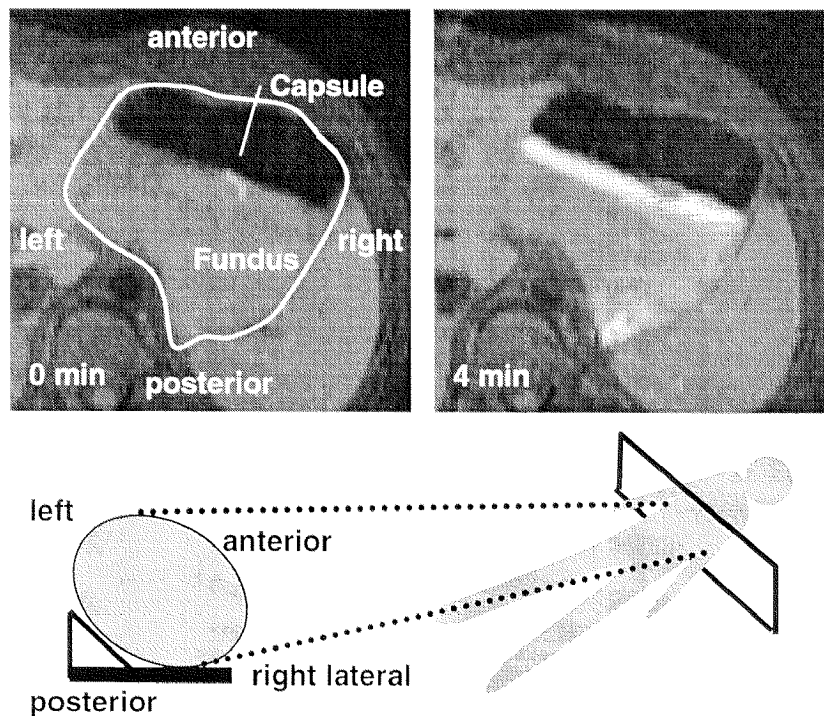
MR images at two time points showing distribution of the liposomes in the fundus after ingestion of a liquid meal. Subjects were in a supine 30° right angled position. Following release from the capsule, Gd-DOTA filled liposomes provided a high signal intensity in the images.
